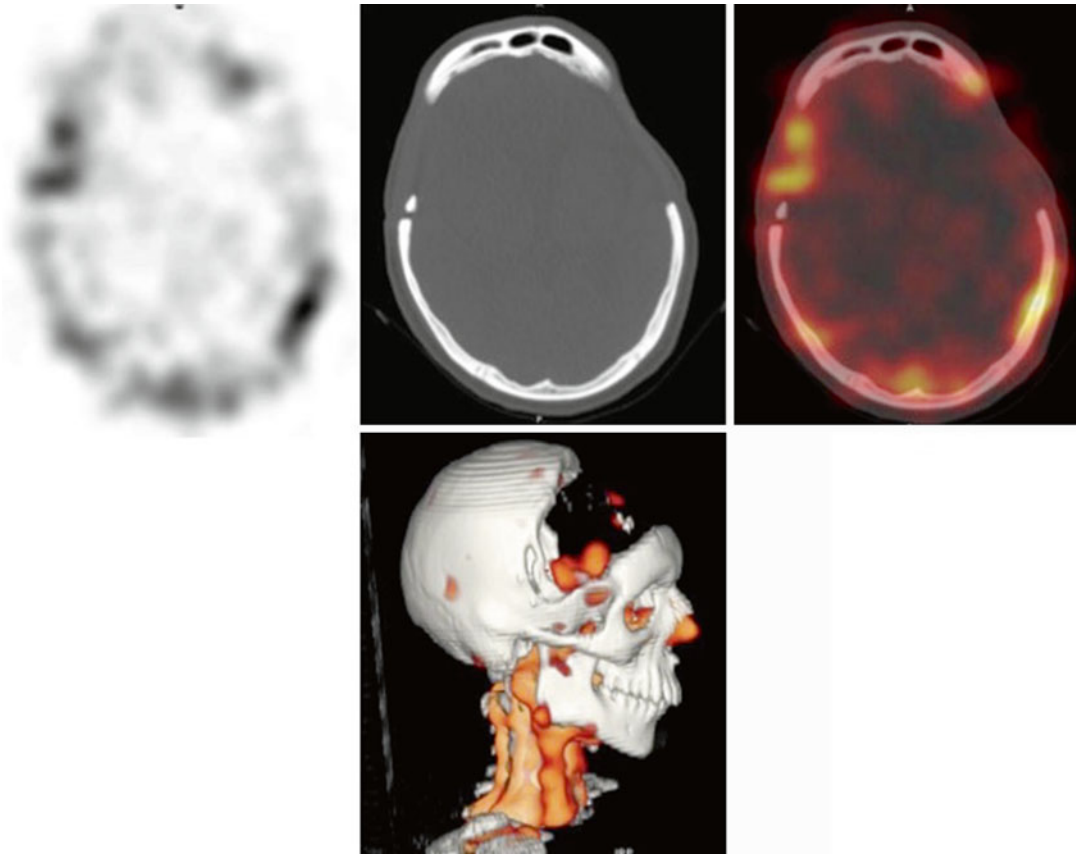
^{99m}Tc -HMPAO WBC SPECT/CT of a patient with brain infection after neurosurgery
